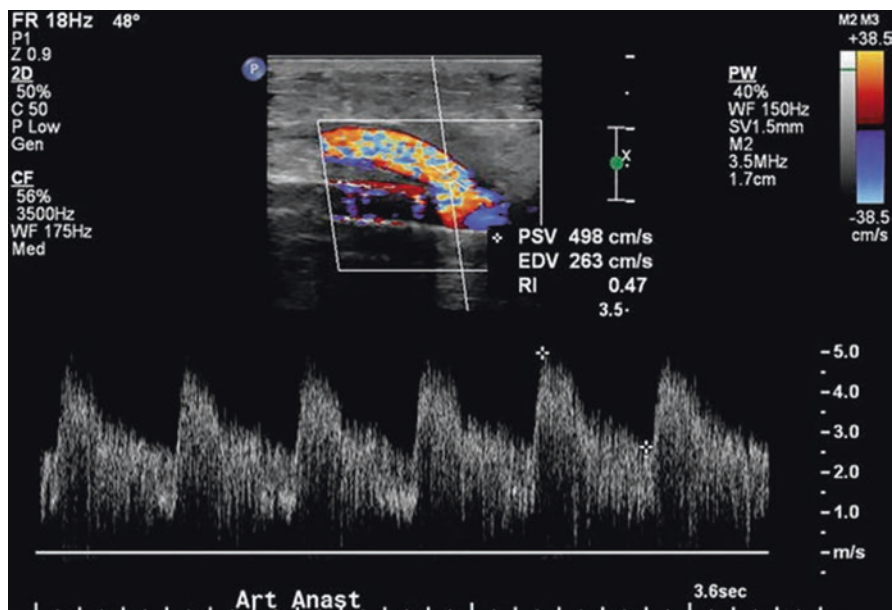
Duplex Doppler image of the same arterial anastomosis as seen in Figs. 10.1 and 10.3. The waveform is velocity on the Y-axis and time on the X-axis. Note the spectral broadening or filling in of the waveform. This correlates with the mixing of the blue and red colors on color Doppler. The angle of incidence is 48 degrees as indicated in the upper left hand corner and the sample volume is very small in within the central flow lumen of the sampled area. The peak systolic velocity and end diastolic velocities are 498 cm/sec and 263 cm/sec, respectively
